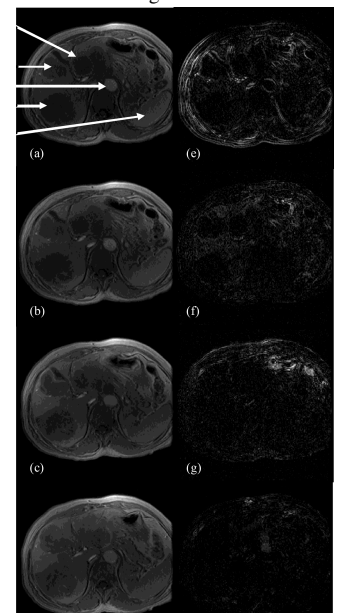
DCE-MRI registration by SER. Arrows point to the aorta, spleen & 3 large hepatic tumors.
